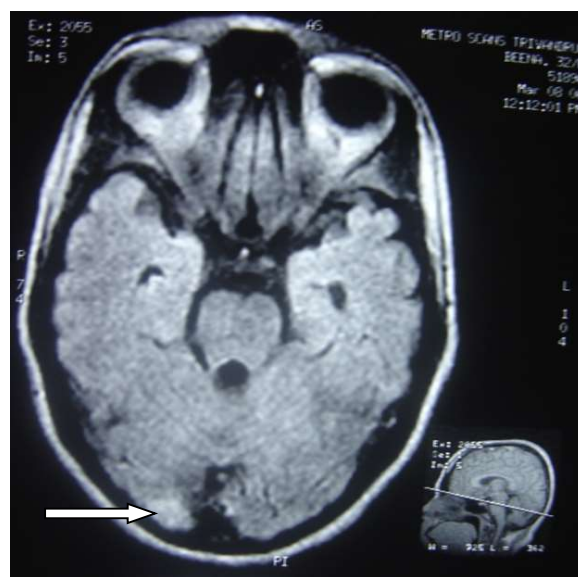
MRI Flair axial section - Hyper intense lesion in the right occipital lobe
